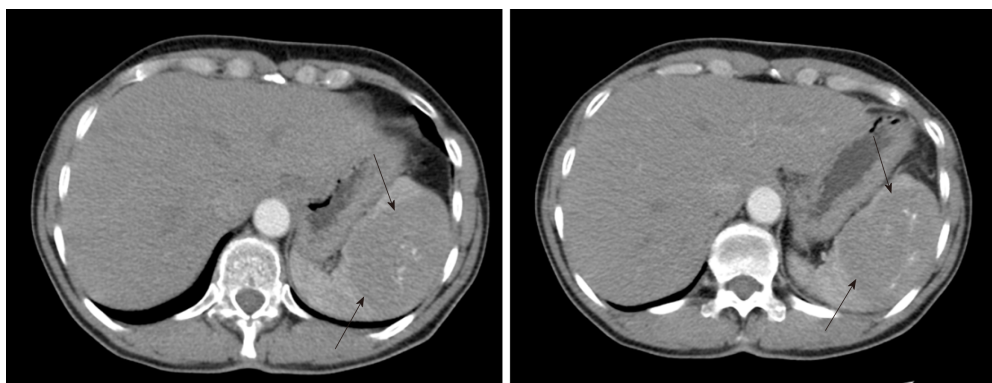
Abdomen computed tomography of a 65-year-old female patient showing a 74 mm × 54 mm solid splenic lesion (marked with arrows).
